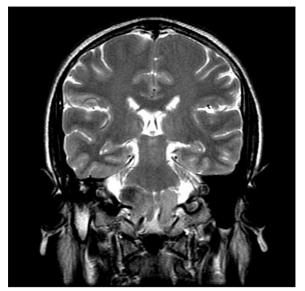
Coronal T2-weighted image of the brain shows hypointense signal of the lesion as compared to the cerebrospinal fluid.
